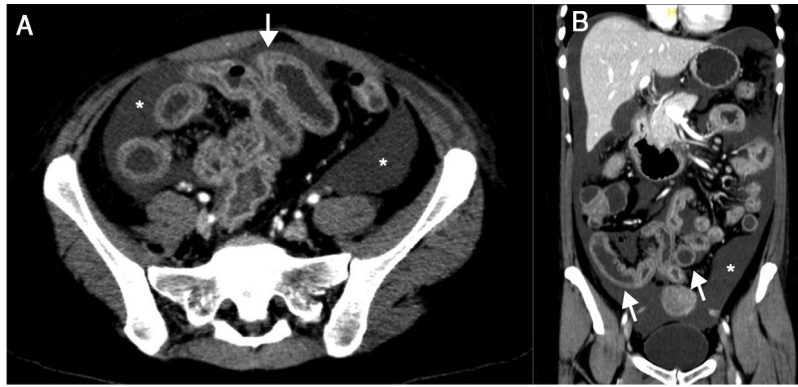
Abdominal CT scan. Diffuse thickening of the bowel loops (arrows) can be seen, as well as diffuse ascites (asterisks) in cross-sectional (A) and coronal (B) views.
